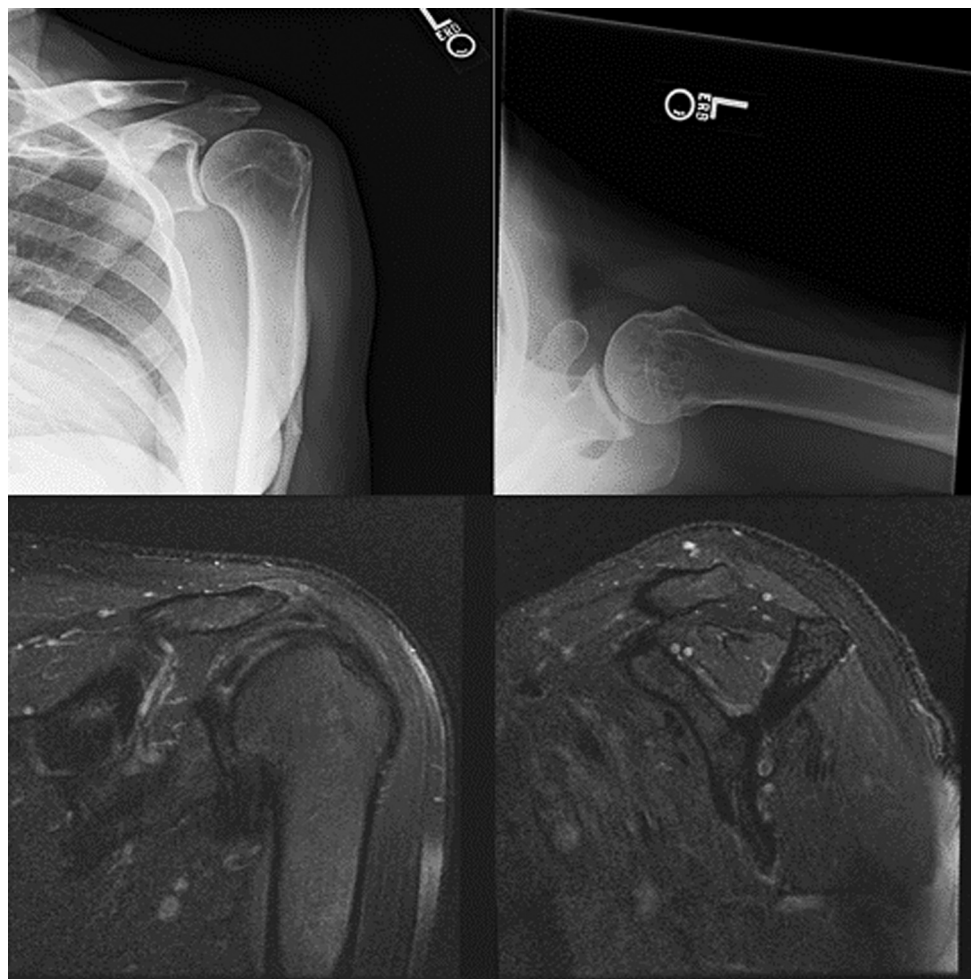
Grashey and axillary X-rays of the patient demonstrating mild glenohumeral arthritis. The T2-fat-suppressed MRI image demonstrating mild edema within the deltoid and supraspinatus muscle belly. *MRI*, magnetic resonance imaging.
